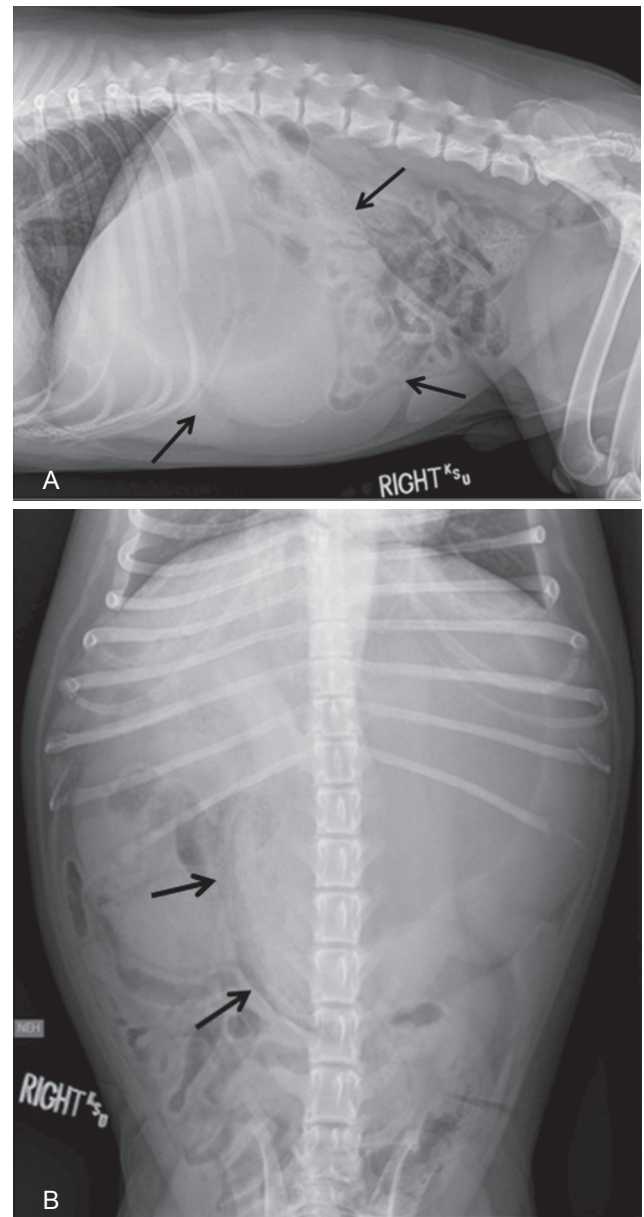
The same radiographic images as in Figure 1. A – A severely fluid and gas distended stomach (arrows) is suggestive of a mechanical or functional gastric outflow obstruction. B – Linear soft tissue opacity material is located within a distended loop of small intestine (arrows) suggestive of a small intestinal foreign body.
